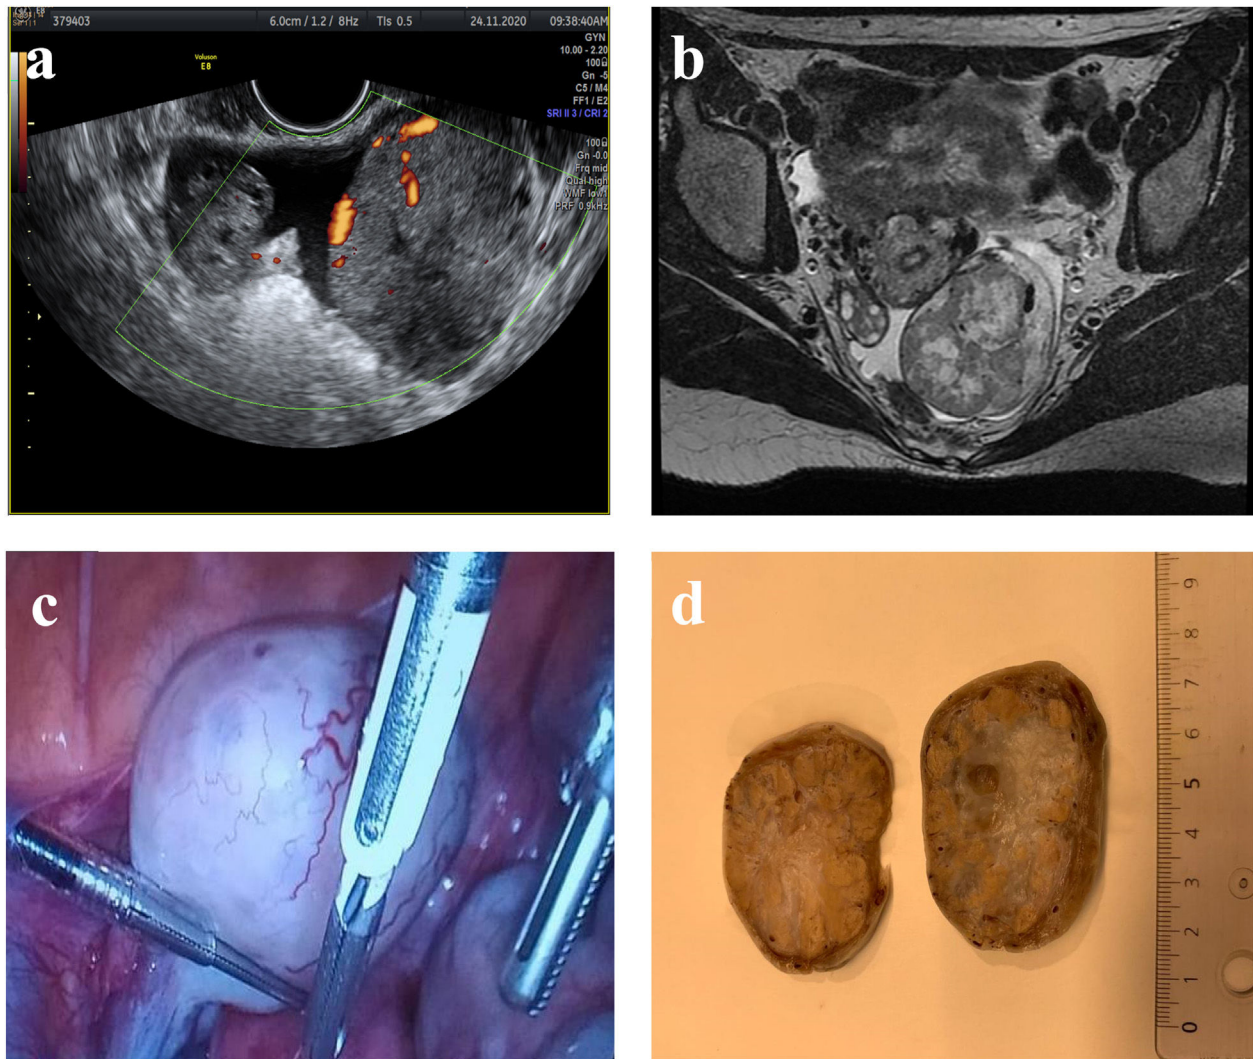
(a) Transvaginal ultrasound revealed a solid hypoechoic tumor with cystic areas and regular borders with multiple vessels in the periphery and central part. The right ovary was normal. A small amount of free fluid was present. (b) MRI revealed an ovoid solid tumor with regular contours. (c) On laparoscopy a solid lobulated mass with a high vascularized capsule depending of the left ovary was found. (d) Macroscopic examination revealed a capsulated tumor with firm consistency and yellowish nodular peripheral components and an oedematous central part.
